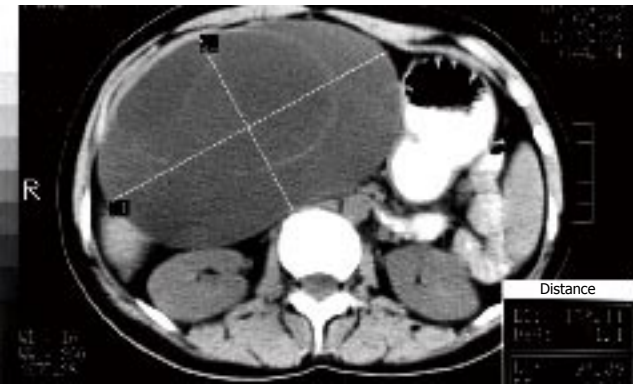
Abdominal CT scan revealing a large binodular cyst occupying most of the right liver lobe.
